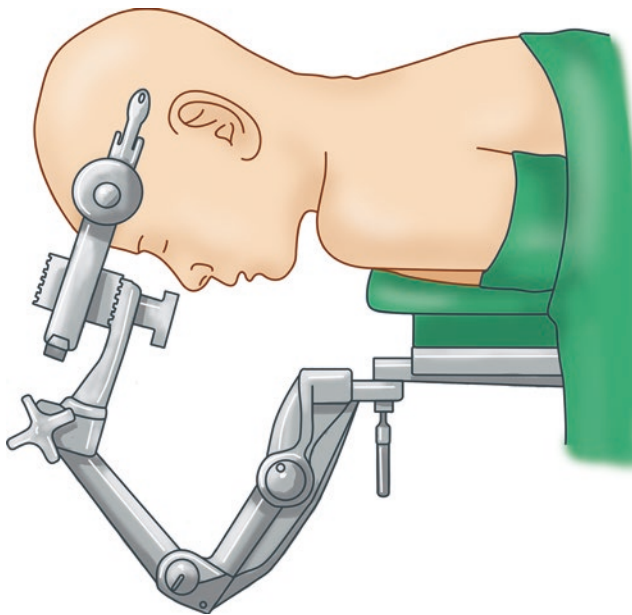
The patient lies prone, with the head secured by a Mayfield skull clamp. The clamp is attached to a Mayfield holder that is connected to the operating table, which maintains the neck in a neutral position. Intraoperative positioning is performed with the aid of the C-arm or CT device
